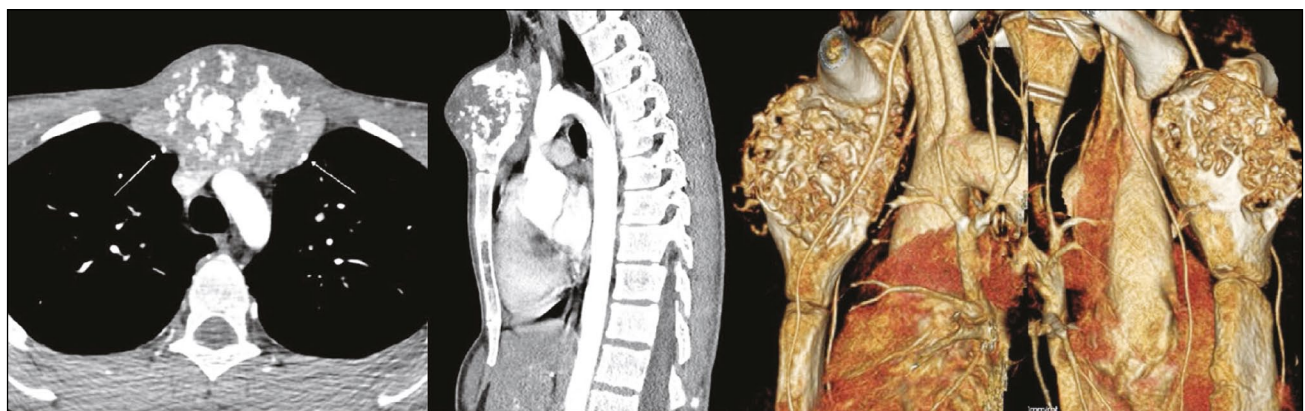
CT arteriography with contrast enhancement of the aorta and internal thoracic artery.
